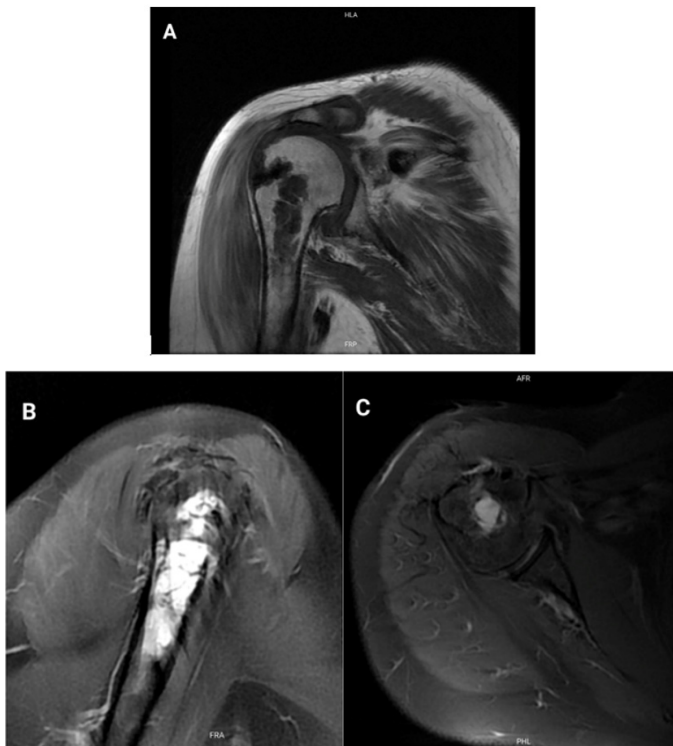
non-contrast MRI of the right shoulder prior to a traumatic event. A. Coronal T1 plane, B. Sagittal plane, C. Axial plane.
